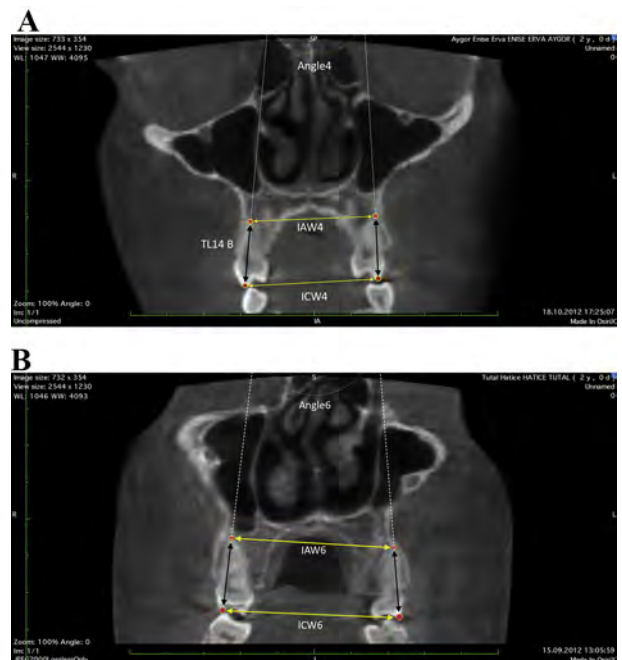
Dental measurements on cone-beam computed tomographic images at the level of maxillary first premolars (A) and the first molars (B).
